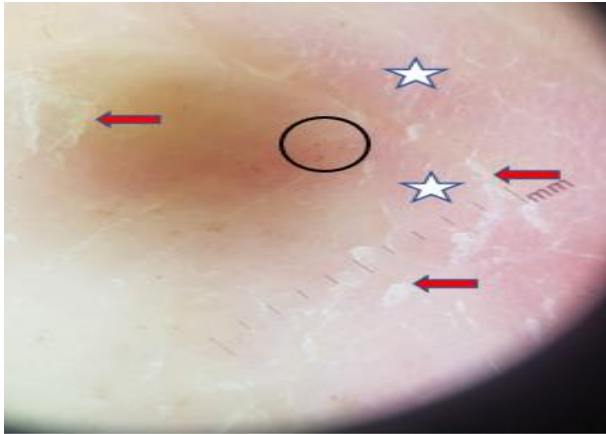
Typical dermoscopic image (non-contact, non-polarized) of a case of plantar psoriasis, showing silvery white scales (red arrow) on an erythematous background (white stars), 10X. This is a dermoscopic image (contact, polarized), of multiple regularly distributed red dots (black circle). The scales are not visible due to the use of a contact medium, which in this case is ultrasound gel. This accentuates the visibility of the underlying vessels.
